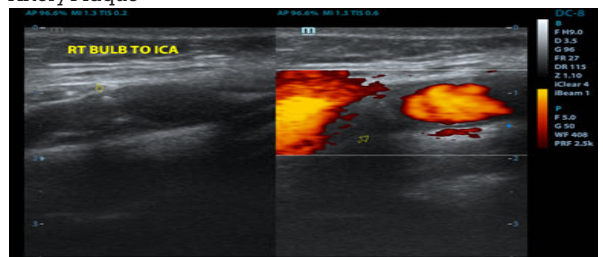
Carotid Doppler Showing Stenosis In Right Bulb To ICA
